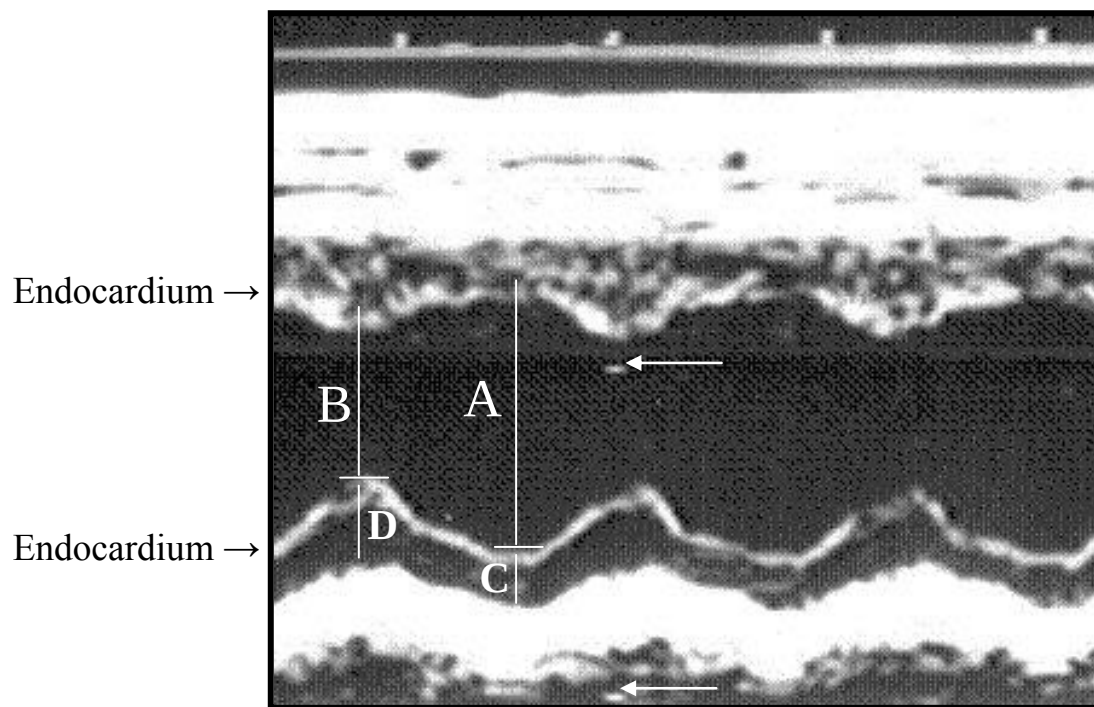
Typical recordings obtained to determine left ventricular dimensions using two-dimensional guided M-mode echocardiography. The white arrows are pointing to calibration markers that indicate a distance of 1 cm.
